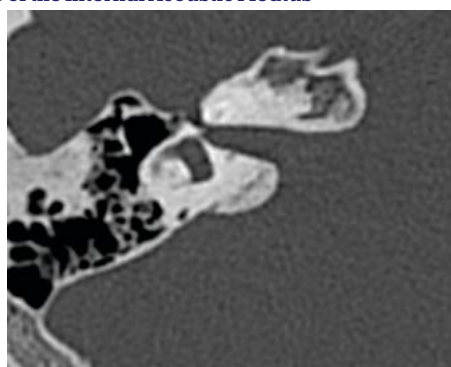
Computed Tomography Image Showing the Funnel Shape of the Internal Acoustic Meatus
